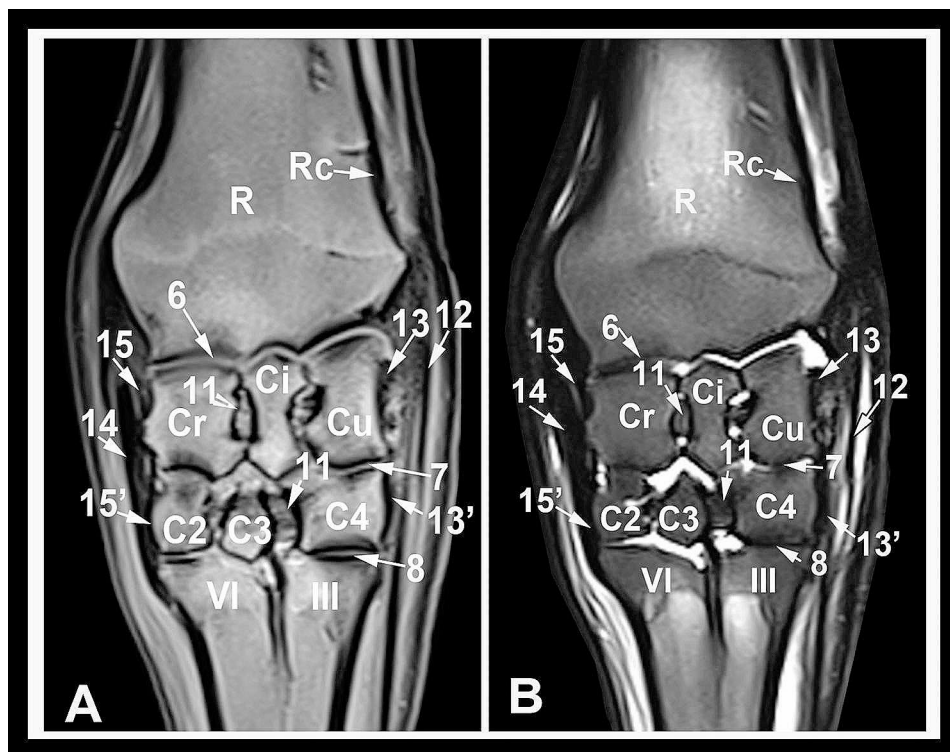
Dorsal T1 (A) and T2-weighted (B) high-field MRI images at the level of the collateral ligaments. R, radius; Rc, radial cortical bone; Cu, ulnar carpal bone; Ci, intermediate carpal bone; Cr, radial carpal bone; C2, 2nd carpal bone; C3, 3rd carpal bone; C4, fourth carpal bone; III, 3rd metacarpal bone; VI, fourth metacarpal bone; 6, articular cartilage of the antebrachio-carpal joint; 7, articular cartilage of the middle inter-carpal joint; 8, articular cartilage of the carpometacarpal joint; 11, short intercarpal ligaments; 12, long lateral collateral carpal ligament; 13, proximal part of the short lateral collateral carpal ligament; 13', distal part of the short lateral collateral carpal ligament; 14, long medial collateral carpal ligament; 15, proximal part of the short medial collateral carpal ligament; 15', distal part of the short medial collateral carpal ligament
